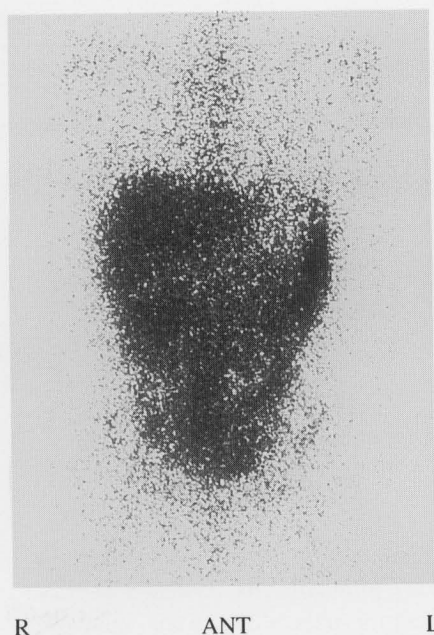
Ga-67 scintigraphy revealed diffuse increased uptake throughout the abdomen.
